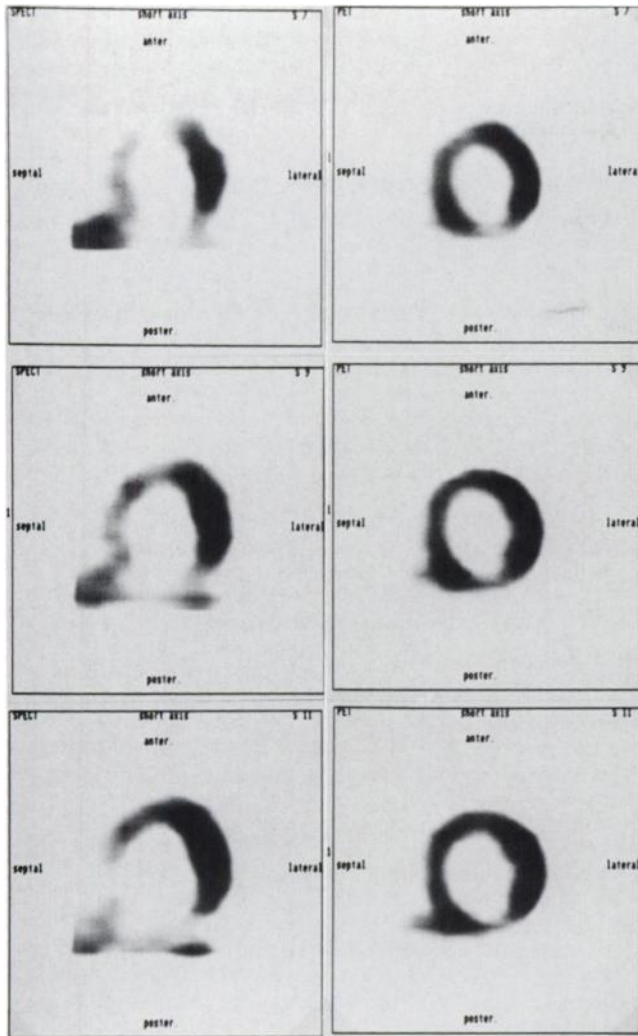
PET (right) demonstrates maintained ^{18}F FDG uptake, indicating preserved myocardial viability in areas of reduced resting perfusion (anterior, septal and posterior) as assessed with $^{99\text{m}}\text{Tc}$ -MIBI SPECT (left). Furthermore, a small area of decreased ^{18}F FDG uptake is noted in the posterior wall after previous posterior wall myocardial infarction. This patient (65-yr-old male) had three-vessel disease with occluded collateralized LAD and RCA and severe LCX stenosis on angiography.
